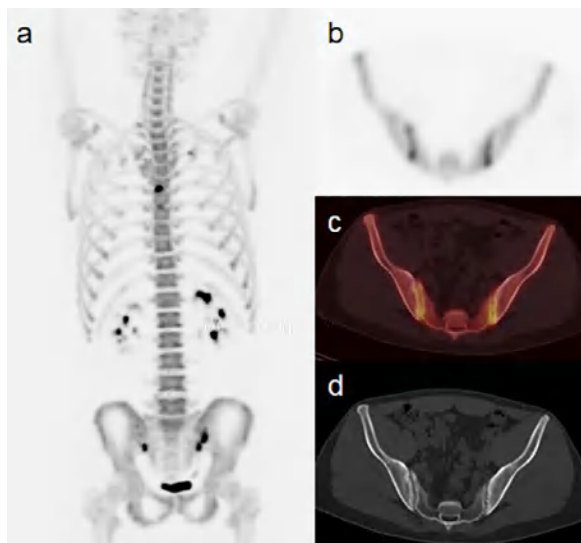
$^{18}\text{F}$ -NaF positron emission tomography image of a 25-year-old patient who was diagnosed with ankylosing spondylitis according to the Assessment of SpondyloArthritis International Society criteria. The maximum intensity projection image (a) and axial images indicates predominant F-18 NaF uptake at the bilateral sacroiliac joint (right maximum standardized uptake value [SUVmax]=9.67 and left SUVmax 21.41; b–d).
